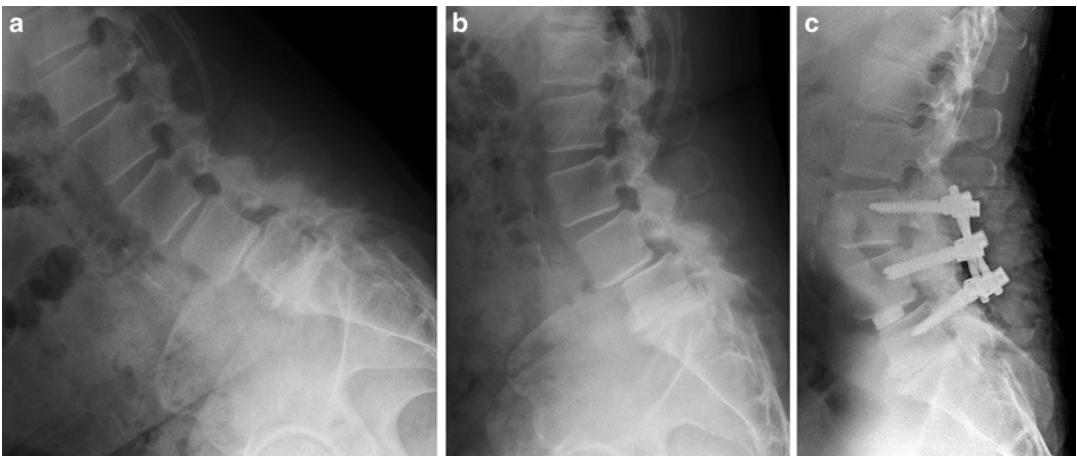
A 55-year-old male presented with neuroclaudication in the legs and severe back pain after having failed nonoperative treatment. (a, b) Flexion and extension radiographs showed an L4–5 degenerative spondylolisthesis with kyphotic collapse as well as a slight spondylolisthesis at L3–4 with fluid in the L3–4 facet
